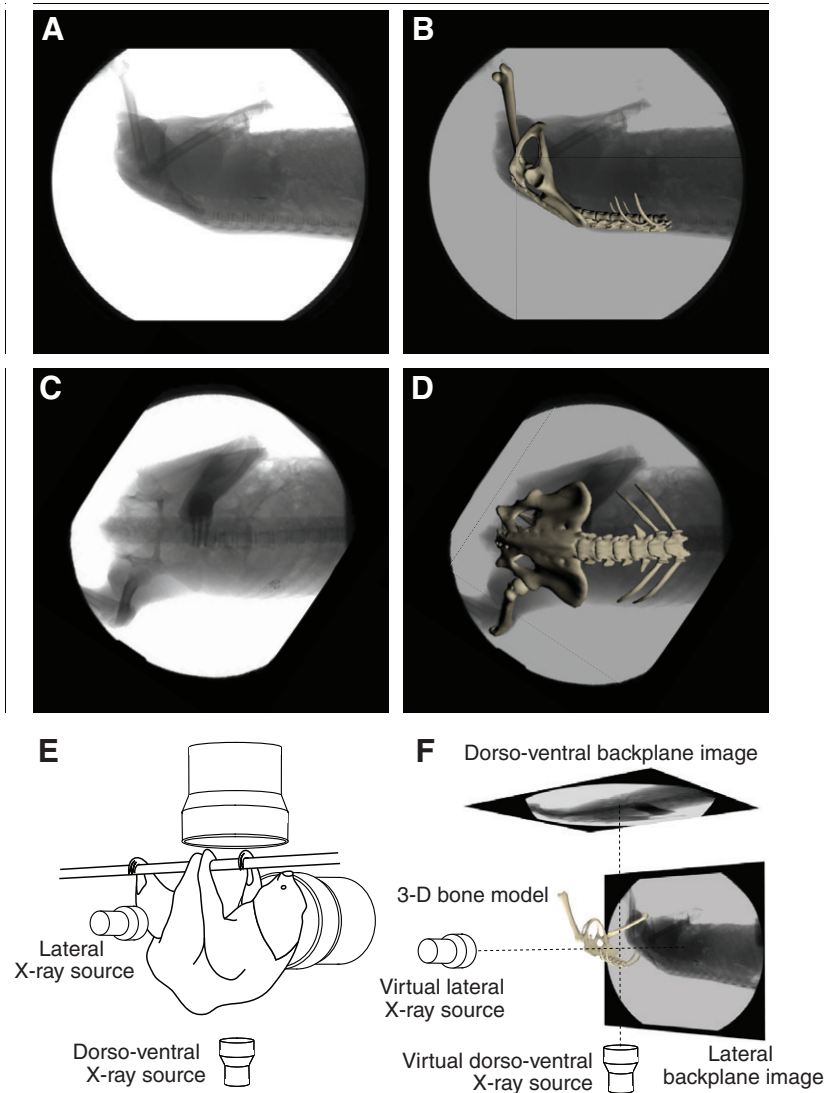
Scientific rotoscopy (Gatesy et al., 2010). A virtual marionette is positioned to match the X-ray shadow of synchronously recorded latero-lateral (A,B) and dorso-ventral (C,D) X-ray videos. This requires the experimental setup (E) to be 3-D calibrated and virtually recreated within the 3-D software Maya™ (F). For further explanation, see Materials and methods.
